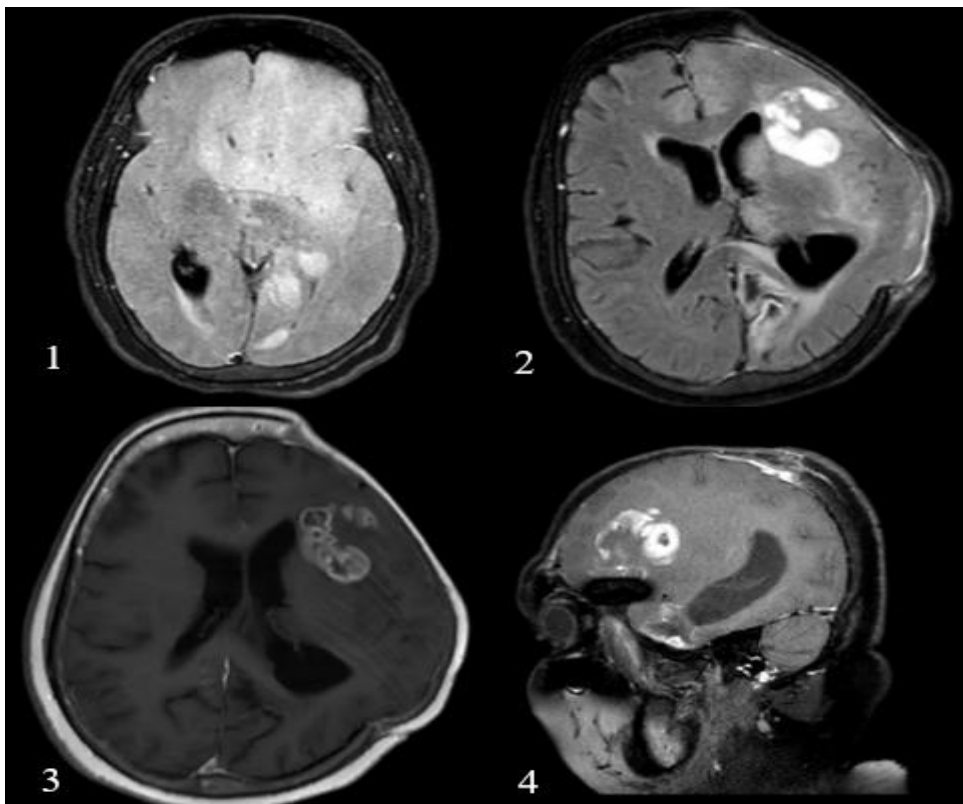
MRI results pre-operatively (1) and post-operatively (2-3-4)
